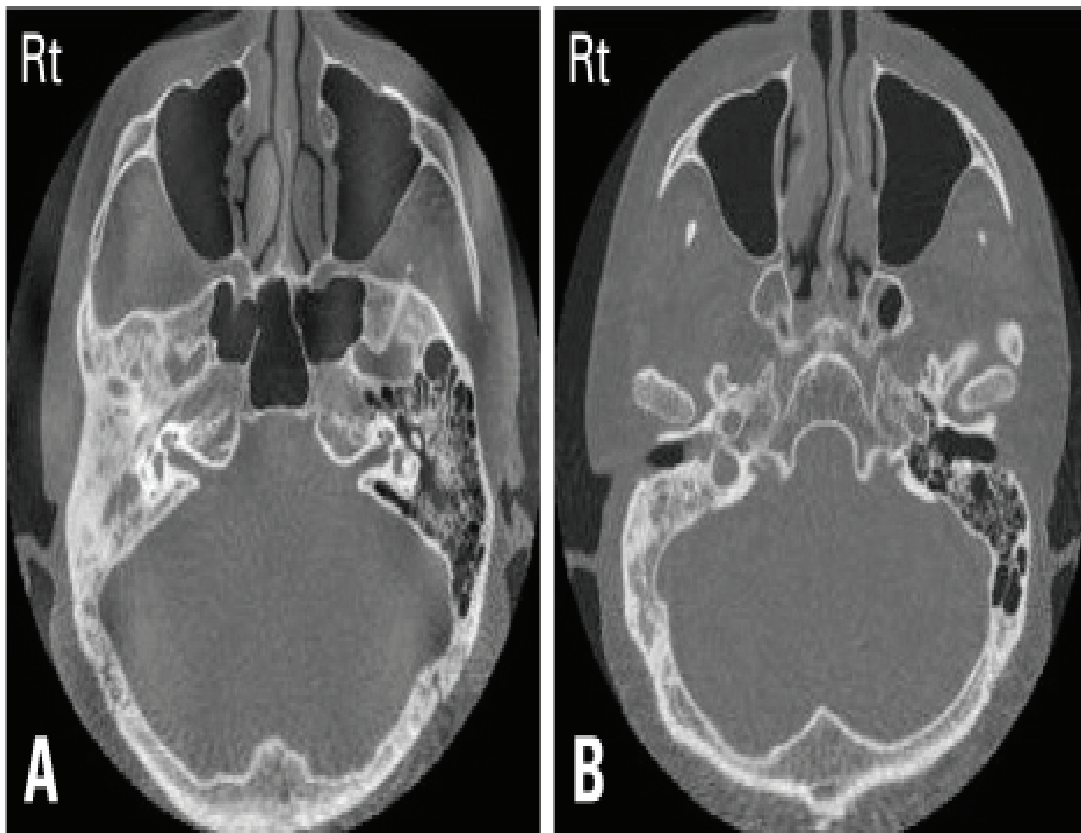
CT scan of damaged mastoid bone
